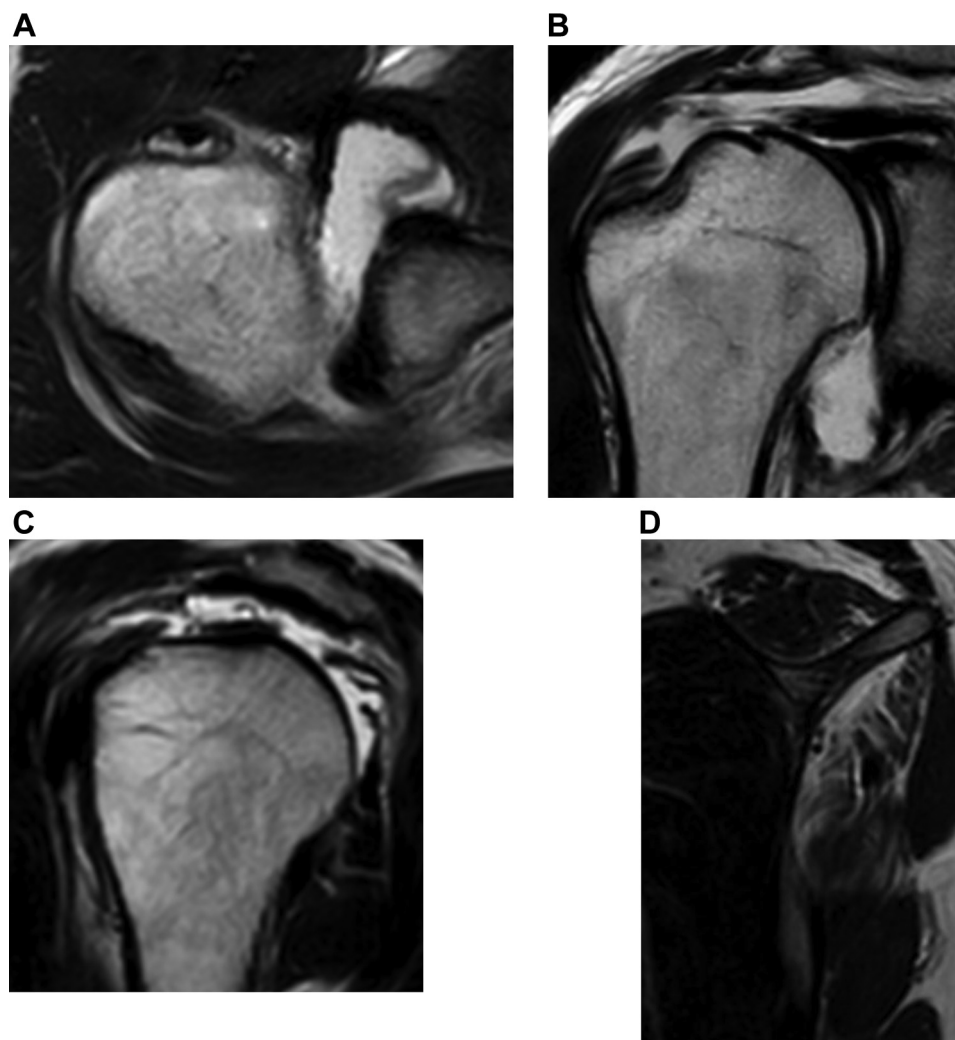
Preoperative magnetic resonance imaging. (A) Axial view. (B) Oblique coronal view. (C) Oblique sagittal view. (D) Oblique sagittal view of the medial muscle of the rotator cuffs.
